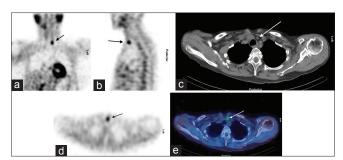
Coronal (a) and sagittal (b) delayed images of dualphase 99m-technetium-sestamibi parathyroid scintigraphy showing persistent focal tracer uptake at the lower pole of the left thyroid lobe (arrows). Axial computed tomography (c), single photon emission computed tomography (d) and fused single photon emission computed tomography-computed tomography (e) images showing 6 mm nodule with high radiotracer uptake inferior and posterior to the lower pole of the left thyroid lobe (arrows), consistent with parathyroid adenoma
